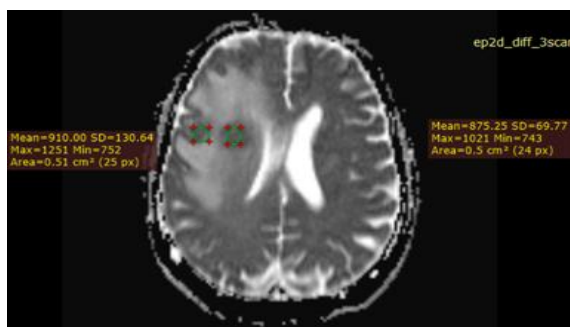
In DWI sequence, the lesion shows diffusion restriction with low ADC values (< 950)
